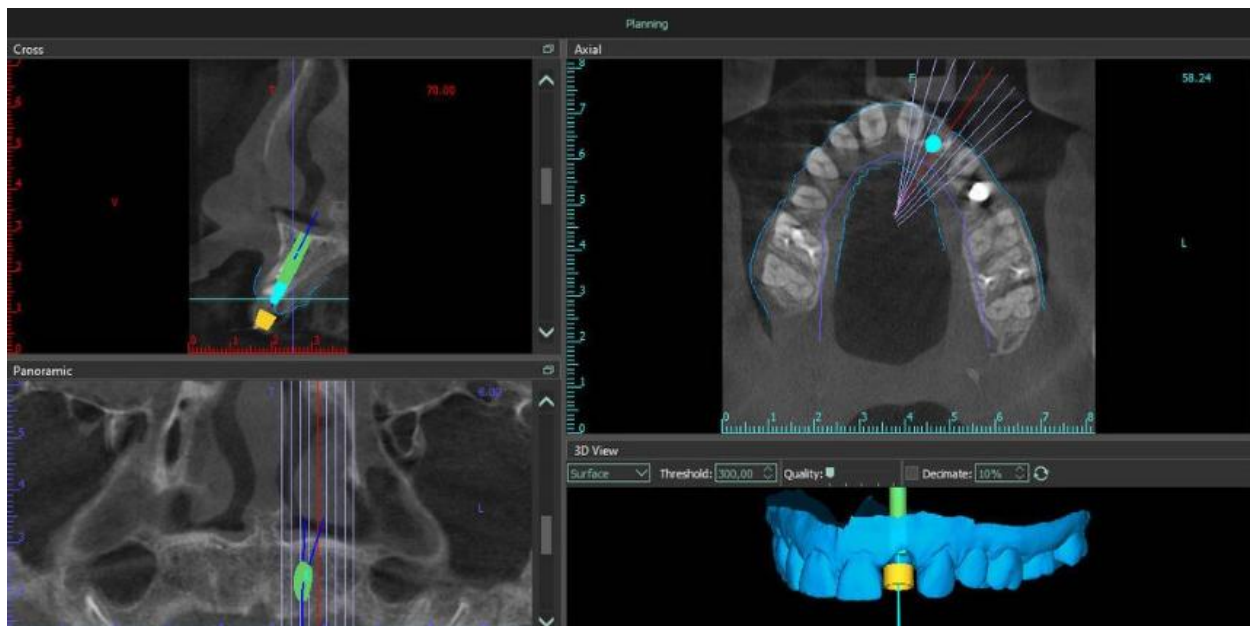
Oral Cavity Imaging via CBCT Technique Performed by the Oral Surgery Robot.
